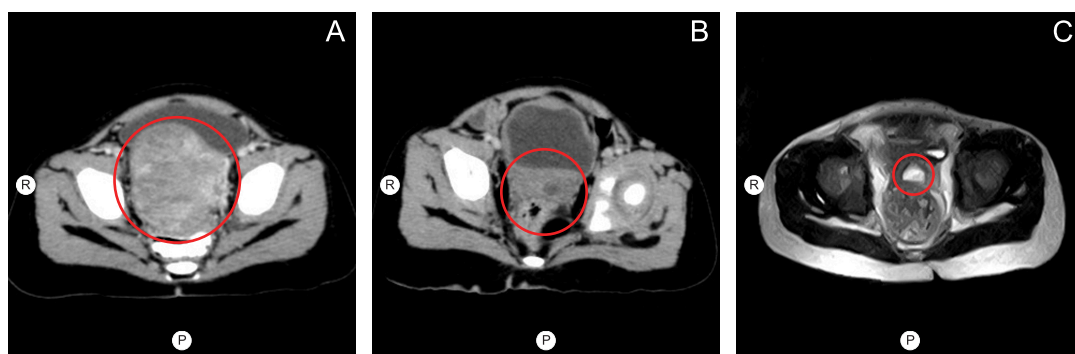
Axial views of abdominal computed tomography (CT) pre-chemotherapy (A), CT post-chemotherapy (B) and magnetic resonance imaging (MRI) 12 weeks post-radiotherapy (C), demonstrating a decrease in the size of the mass in the cervico-uterine region (A, B, and C: red rings). R — right; P — posterior.
